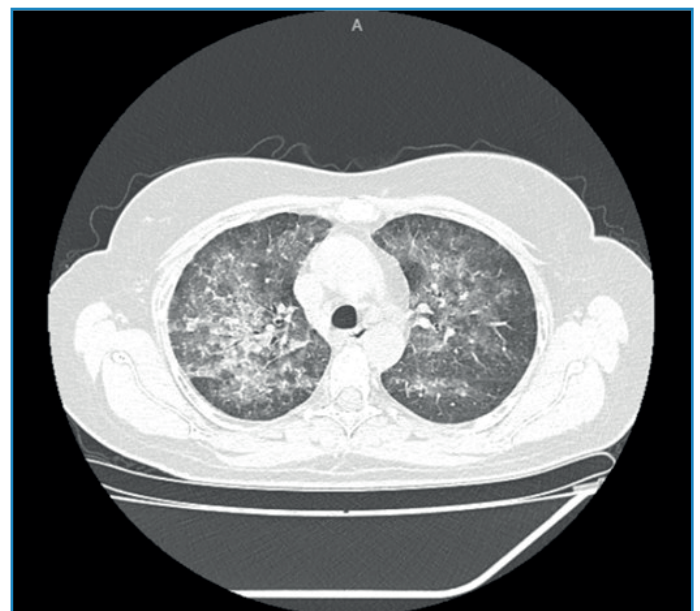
High-resolution computed tomography scan of the chest showing diffuse bilateral ground-glass opacities with interlobular septal thickening that predominantly affected the upper lobes and peribronchovascular regions. These radiological features are characteristic but not pathognomonic of MTX-induced pneumonitis.
